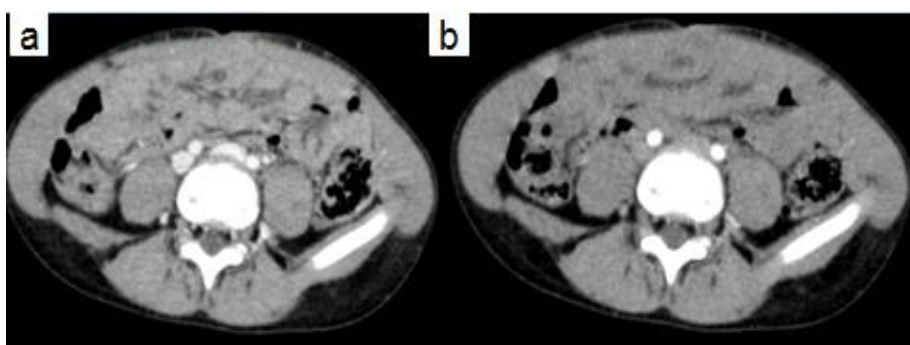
CT scan with contrast (a & b) after surgery showed no evidence of local recurrence
